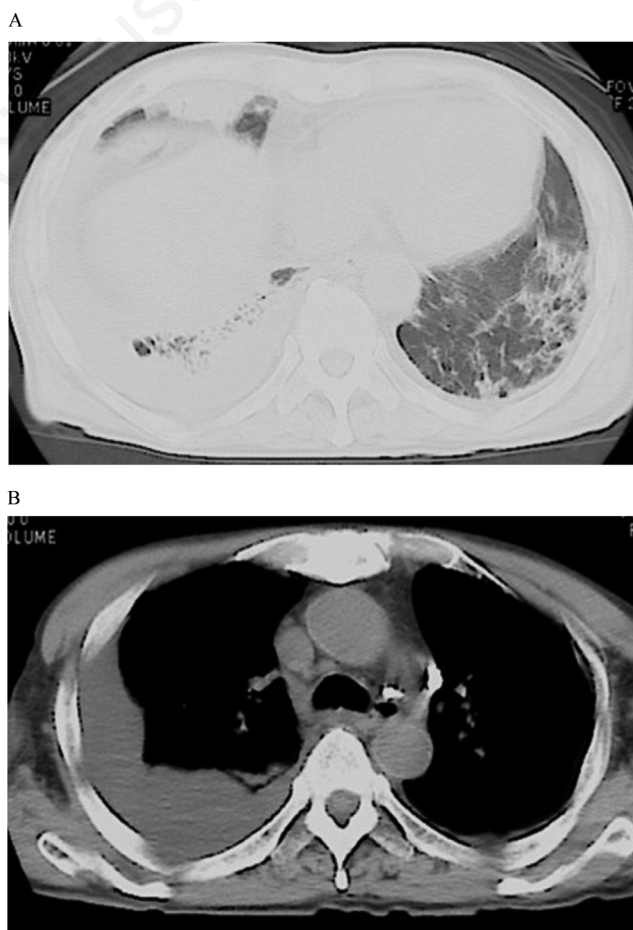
A) Computed tomography of the chest revealing ground-glass opacity, interlobular septal thickening and traction bronchiectasis at both the lower lobes. B) Pleural effusion was more predominant in the right lung than the left lung.
